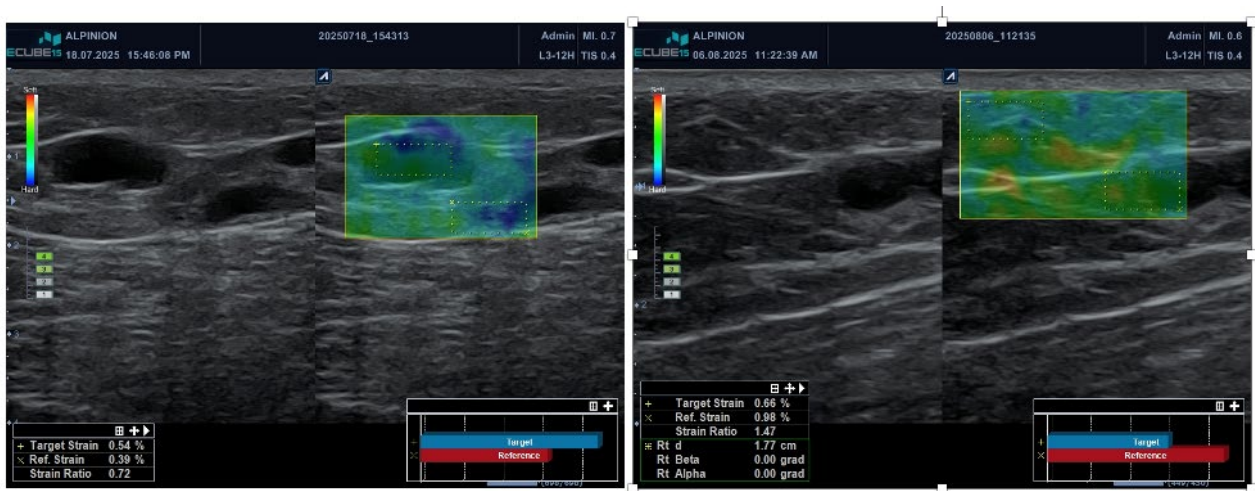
Color Doppler elastosonography of the right gluteus showing progressive improvement, reduction of nodular fibrotic changes, and preservation of the implant.
